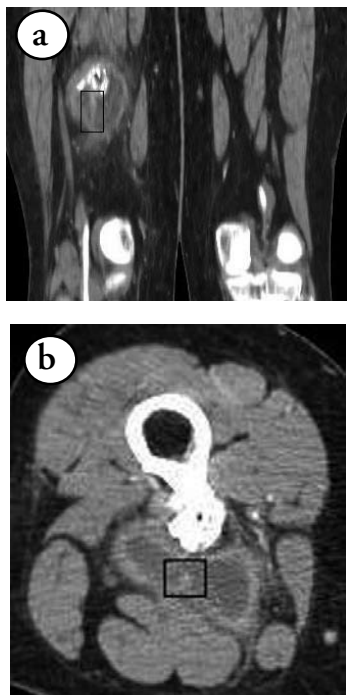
Preoperative computed tomography angiogram showing the vein inside the bursa still patent a) coronal reformat, b) axial view.
